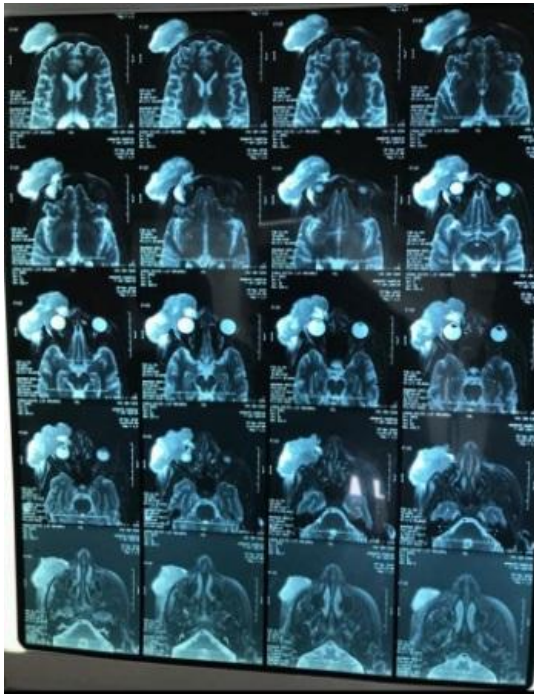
Images of orbital MRI close contact with the eyeball
